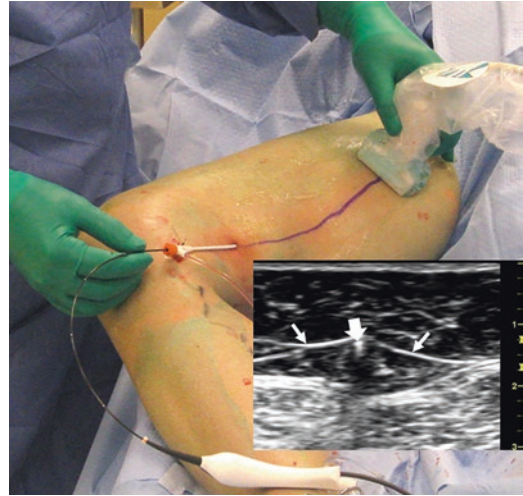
The RFA ablation catheter is advanced up the GSV under ultrasound guidance. The catheter (*large arrow* on ultrasound image) is visualized transversely in the vein which lies within the oval saphenous fascia (*thin arrows*)
